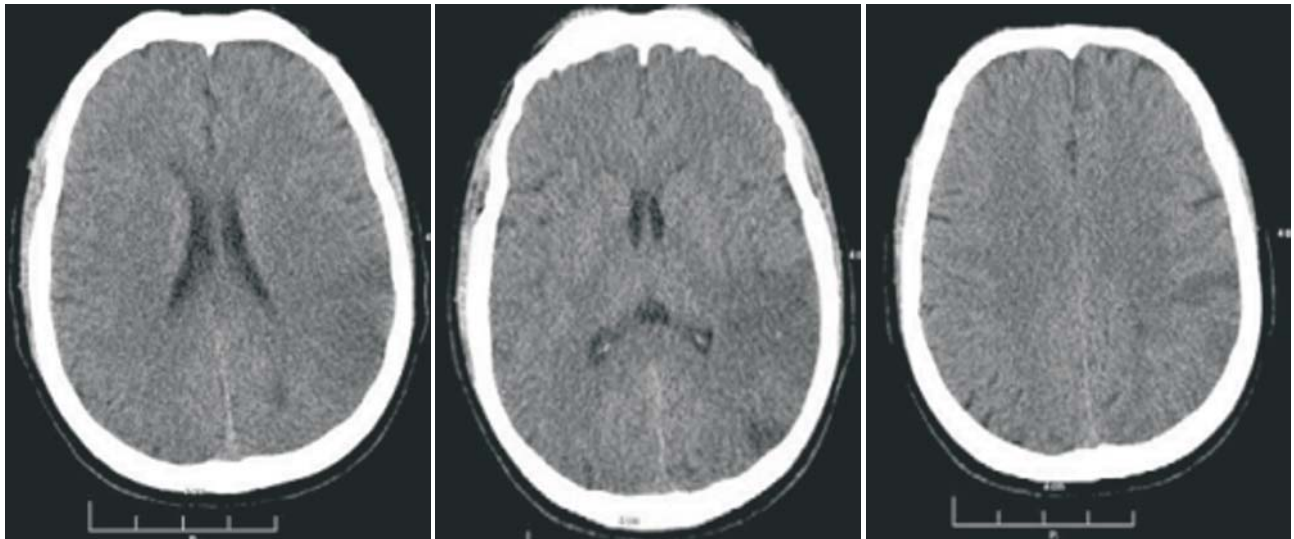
Second control CT (24h after the onset) - ischemic zone in left parietal lobe; with reversal of neurological deficits - NIHSS 3 points
